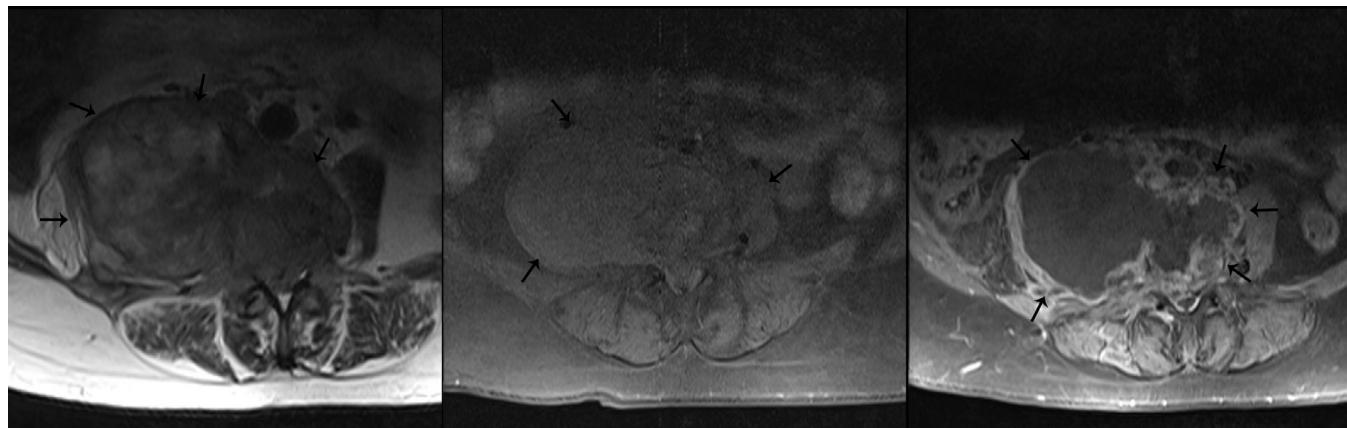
Axial T2-weighted (Left), non-contrast fat-saturated T1-weighted (Middle) and contrast-enhanced fat-saturated T1-weighted (Right) MR images show heterogeneous lesion with peripheral enhancement in the right psoas muscle associated with bone involvement of the lumbar vertebrae (arrows).
